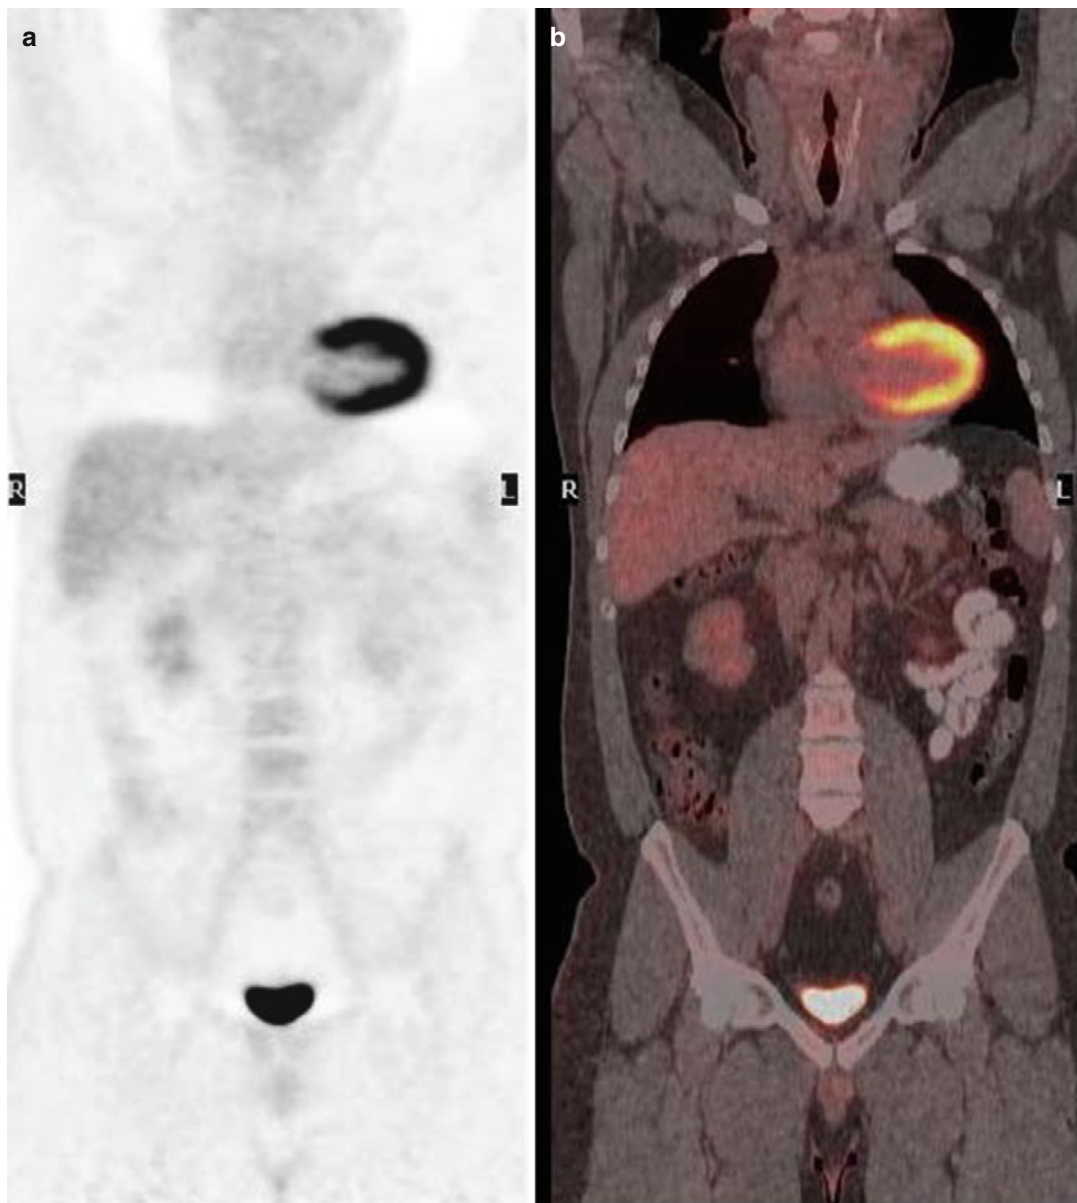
Interim PET/CT evaluation was completely negative (D5- PS score1)
